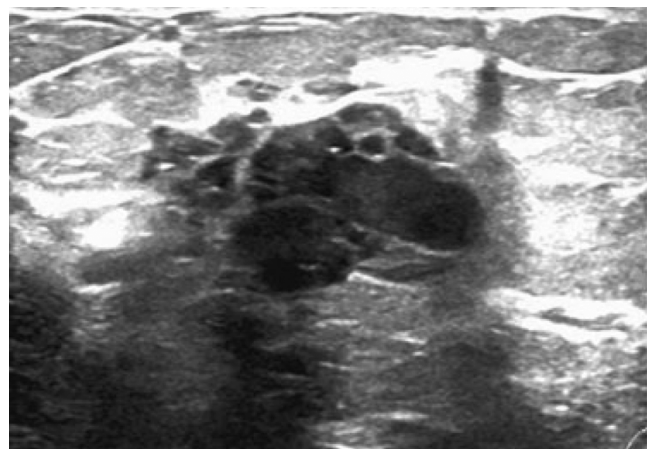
Ultrasound image demonstrating an irregular mass with circumscribed margins. Presence of multiple areas of hypo-echogenicity indicating cystic areas.
